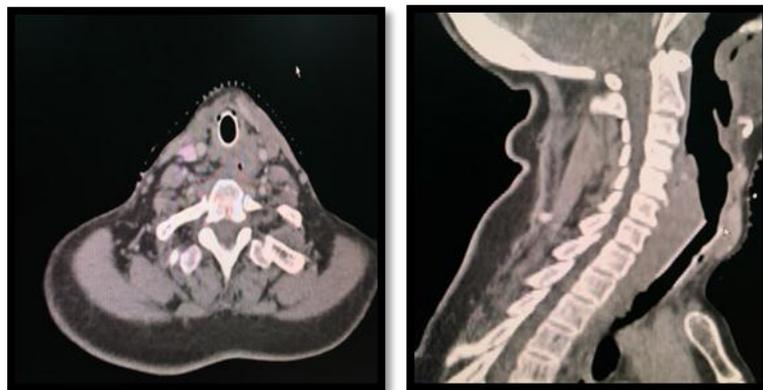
CT-Scan after bronchoscopic resection of the tumor and establishment for an intra luminal stent.
